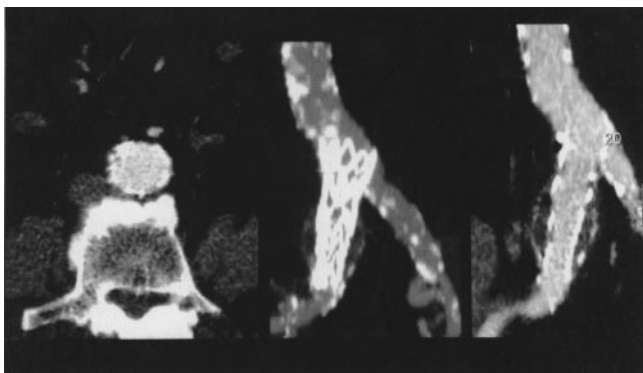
(Observation 2) : CT slice and oblique reconstructions of the aortic bifurcation after the endovascular treatment.
